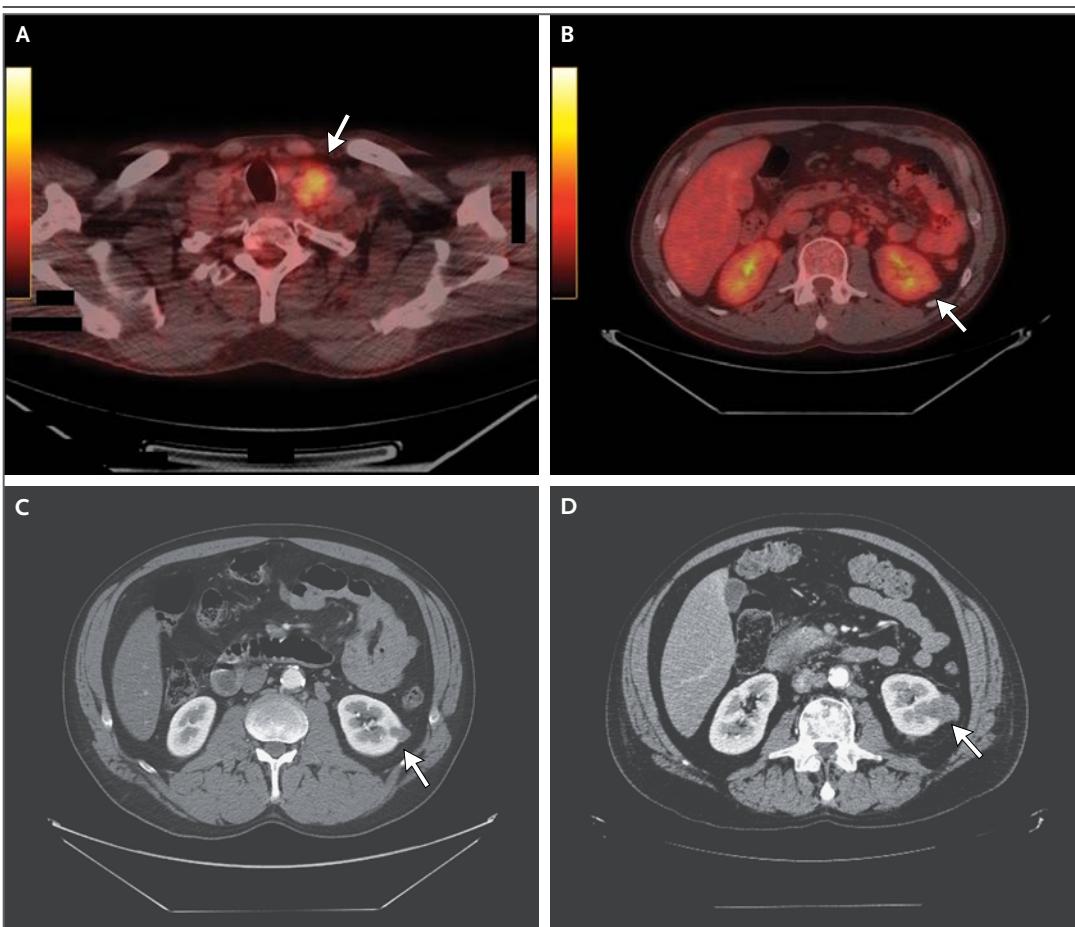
Drawback of Baseline ^{18}F -fluorodeoxyglucose Positron-Emission Tomography (PET)–CT as the Initial Imaging Method in Unknown Primary Cancer.
